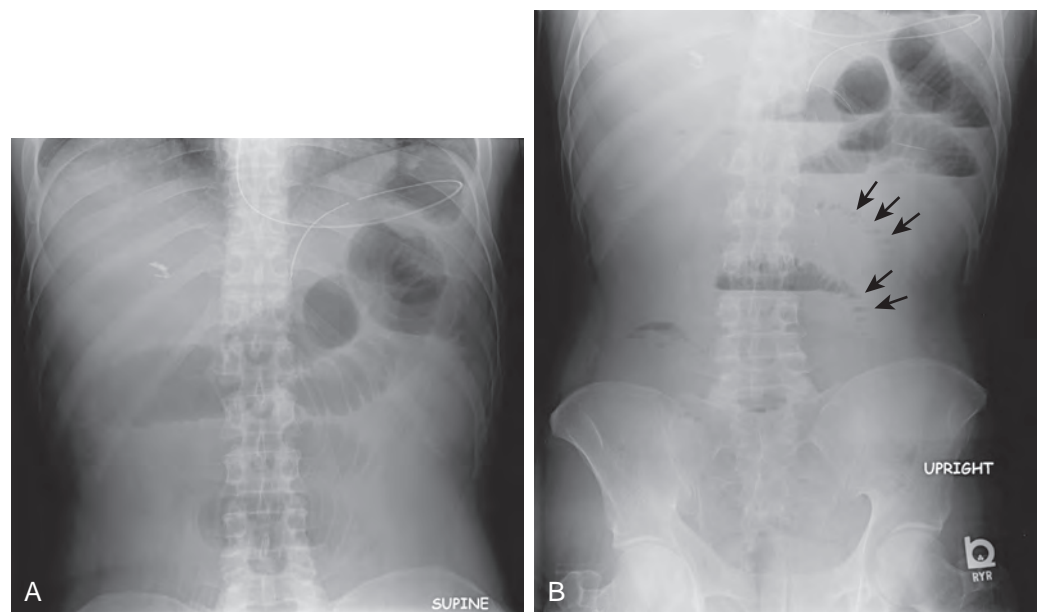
Small bowel obstruction. A. Supine radiograph shows dilated small bowel loops in the upper abdomen, with a paucity of colonic gas. B. Upright radiograph demonstrates multiple air-fluid levels. Small amounts of gas trapped between small bowel folds in the left midabdomen (arrows) produce the string of pearls sign.
